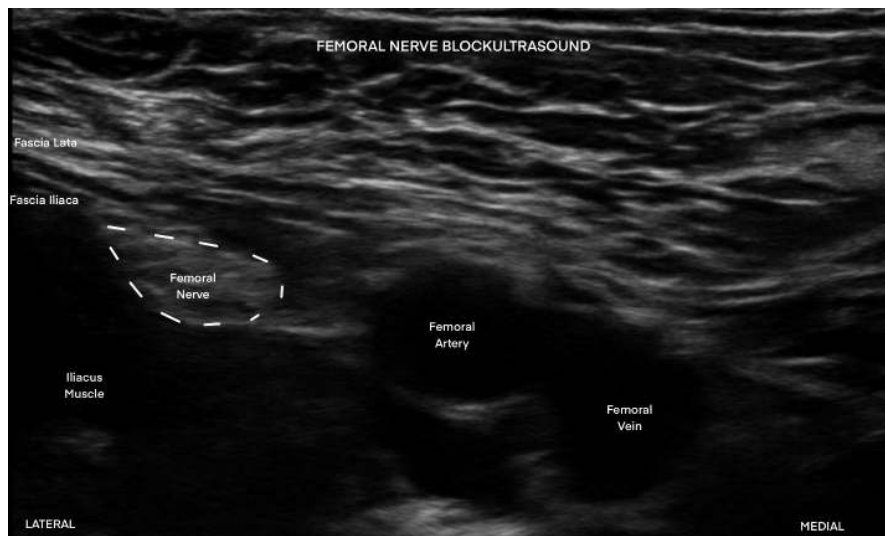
Ultrasound image of the inguinal area, depicting the normal relationship between the femoral vein, femoral artery, and femoral nerve. The mnemonic “VAN” can be used to remember the orientation of these structures in the medial to lateral direction.
